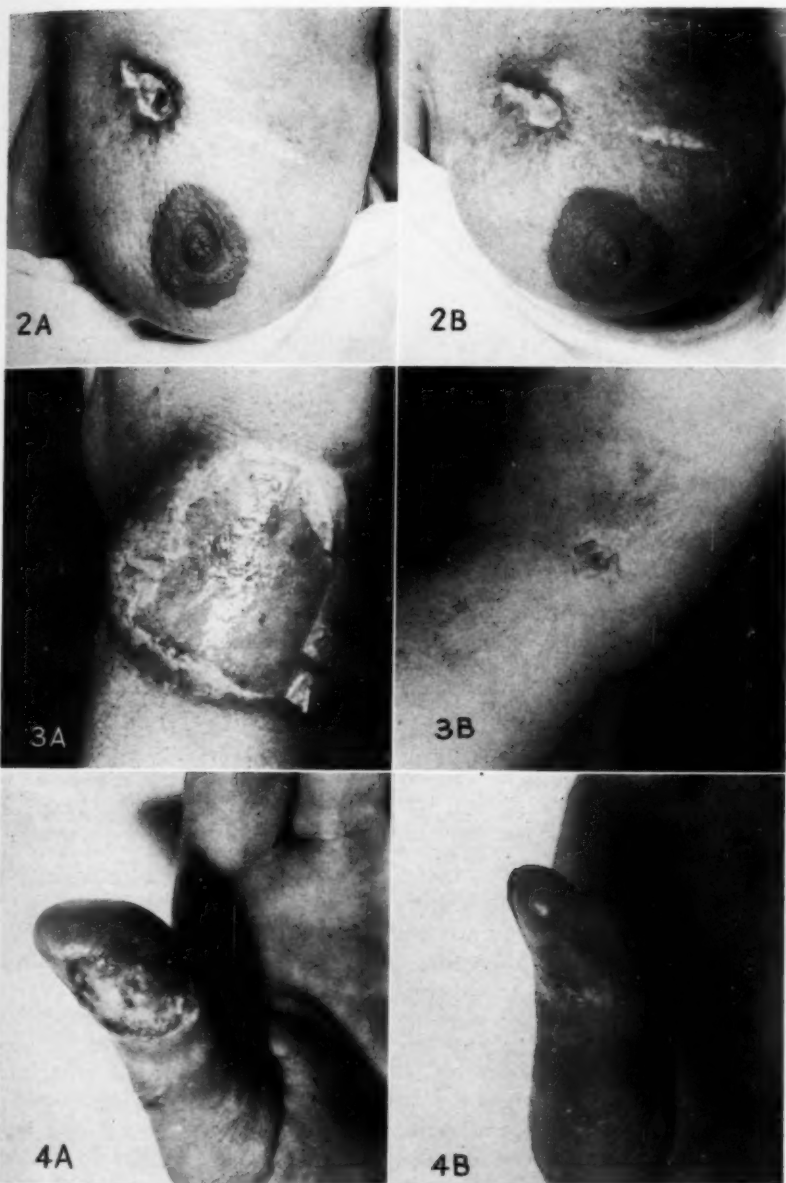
A. Roentgen injury of right breast following prolonged x-ray treatment, supposedly for breast carcinoma, no biopsy having been taken. B. Healing with complete epithelialization of the ulcer, following nine applications of radon ointment.
